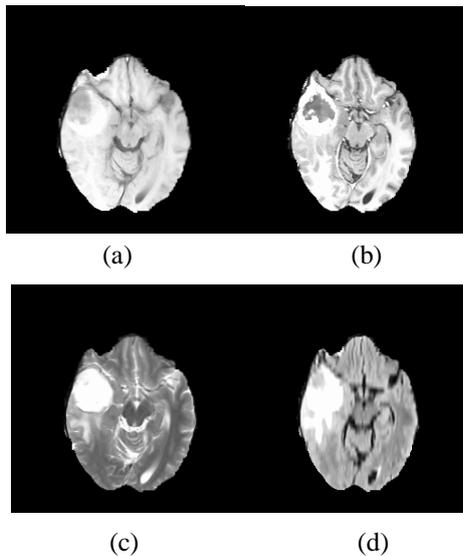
MRI brain scan with tumor (a) T1 Scan (b) T1c Scan (c) T2 Scan (d) FLAIR Scan
